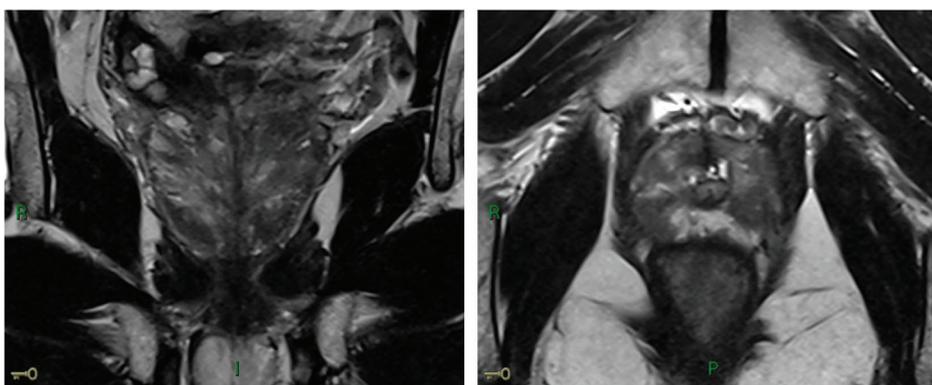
Multiparametric nuclear MRI of the prostate, July 2022.
